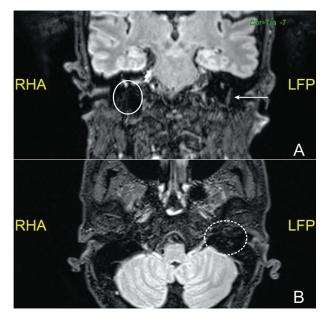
(A) 3D - FLAIR image on coronal plane shows high signal intensity of the descending segment of the left facial nerve (white narrow). No abnormal signal of the descending of the right facial nerve is seen (white circle). (B) No abnormal signal of the geniculate ganglion is seen (dash circle).
